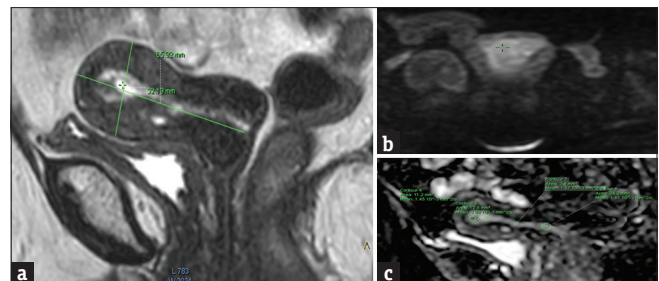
Endometrial polyp in a 50-year-old perimenopausal woman shows representative magnetic resonance imaging findings in a majority of our cases. (a) T2-weighted image in sagittal plane shows a polyp with slightly low signal intensity compared with normal endometrium. There is low signal intensity central fibrous cores (yellow arrow) and small high signal intensity intratumoral cyst (blue arrow). (b) diffusion-weighted image with b value of 1000s/mm² in the sagittal plane at the same level as in A shows a polyp with low signal intensity compared with endometrium. (c) Apparent diffusion coefficient reveals a value of 1.4 in the fibrous core and 1.6–2.0 in the polyp and intratumoral cyst
